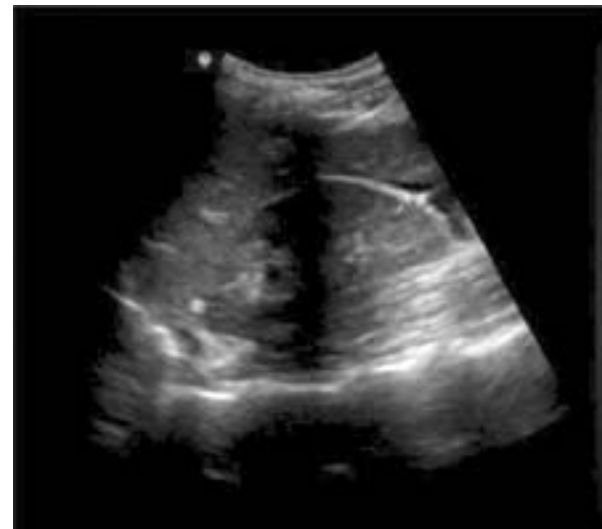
A positive Focused Assessment with Sonography for Trauma (FAST) examination. Ultrasound image demonstrating a small amount of free fluid adjacent to the liver in Morrison's pouch.
